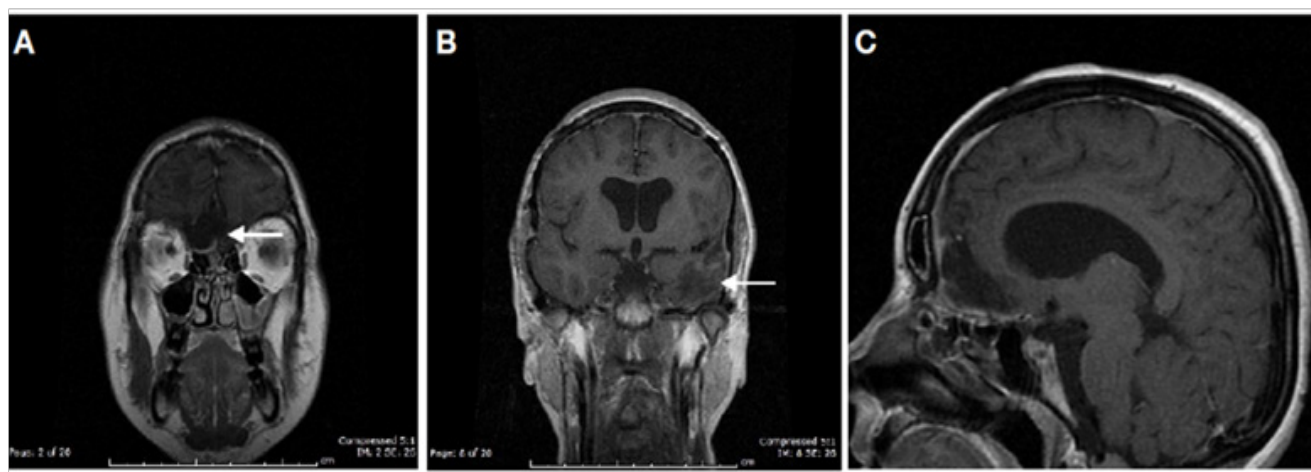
(A,B,C) Postoperative T1 Gadolinium enhanced coronal and sagittal MRI shows complete resection of olfactory groove meningioma and left sphenoidal meningioma. White arrows show the place where the tumors were previous to surgical resection.
